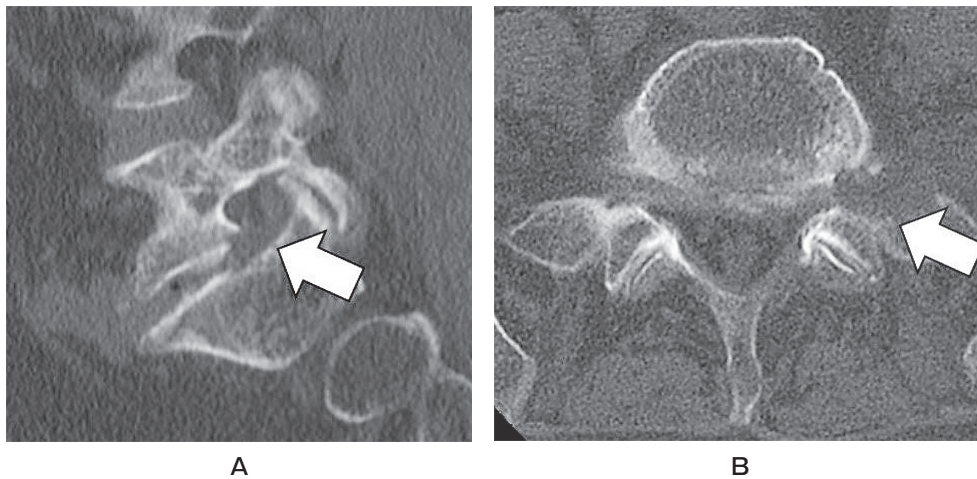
A, A postoperative CT scan sagittal section shows adequate decompression of the foramen and extraforaminal stenosis (white arrow); B, A postoperative CT scan axial section demonstrates adequate decompression of the foramen and extraforaminal stenosis (white arrow).
